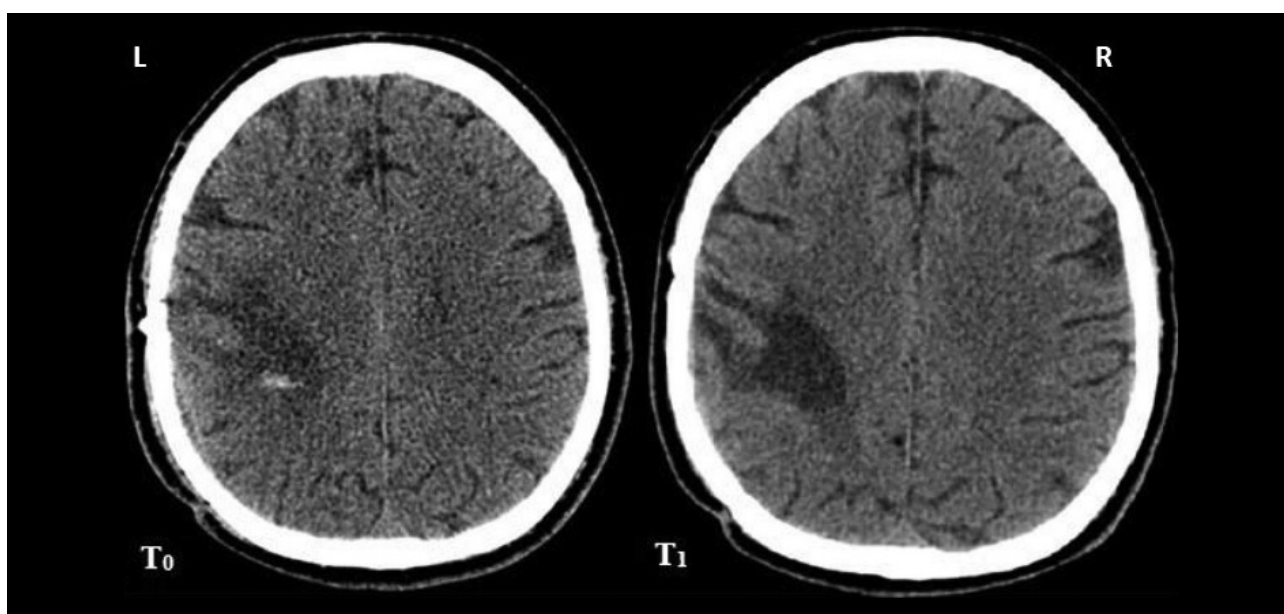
CT at the admission (T_0) at the Maugeri rehabilitative center and at discharge (T_1)
